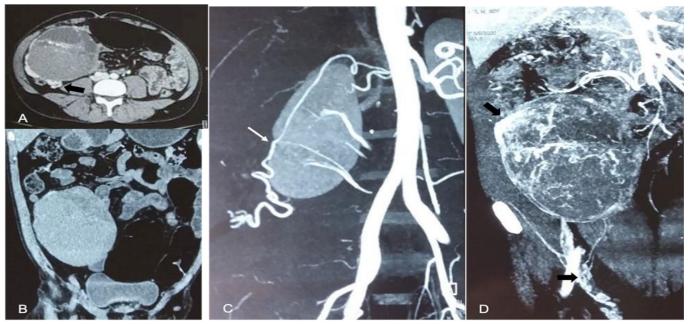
Contrast enhanced CT axial (A), Coronal (B), arterial phase coronal MIP (C) and venous phase coronal MIP (D) images showing well defined heterogeneously enhancing mass in right lower abdomen.
